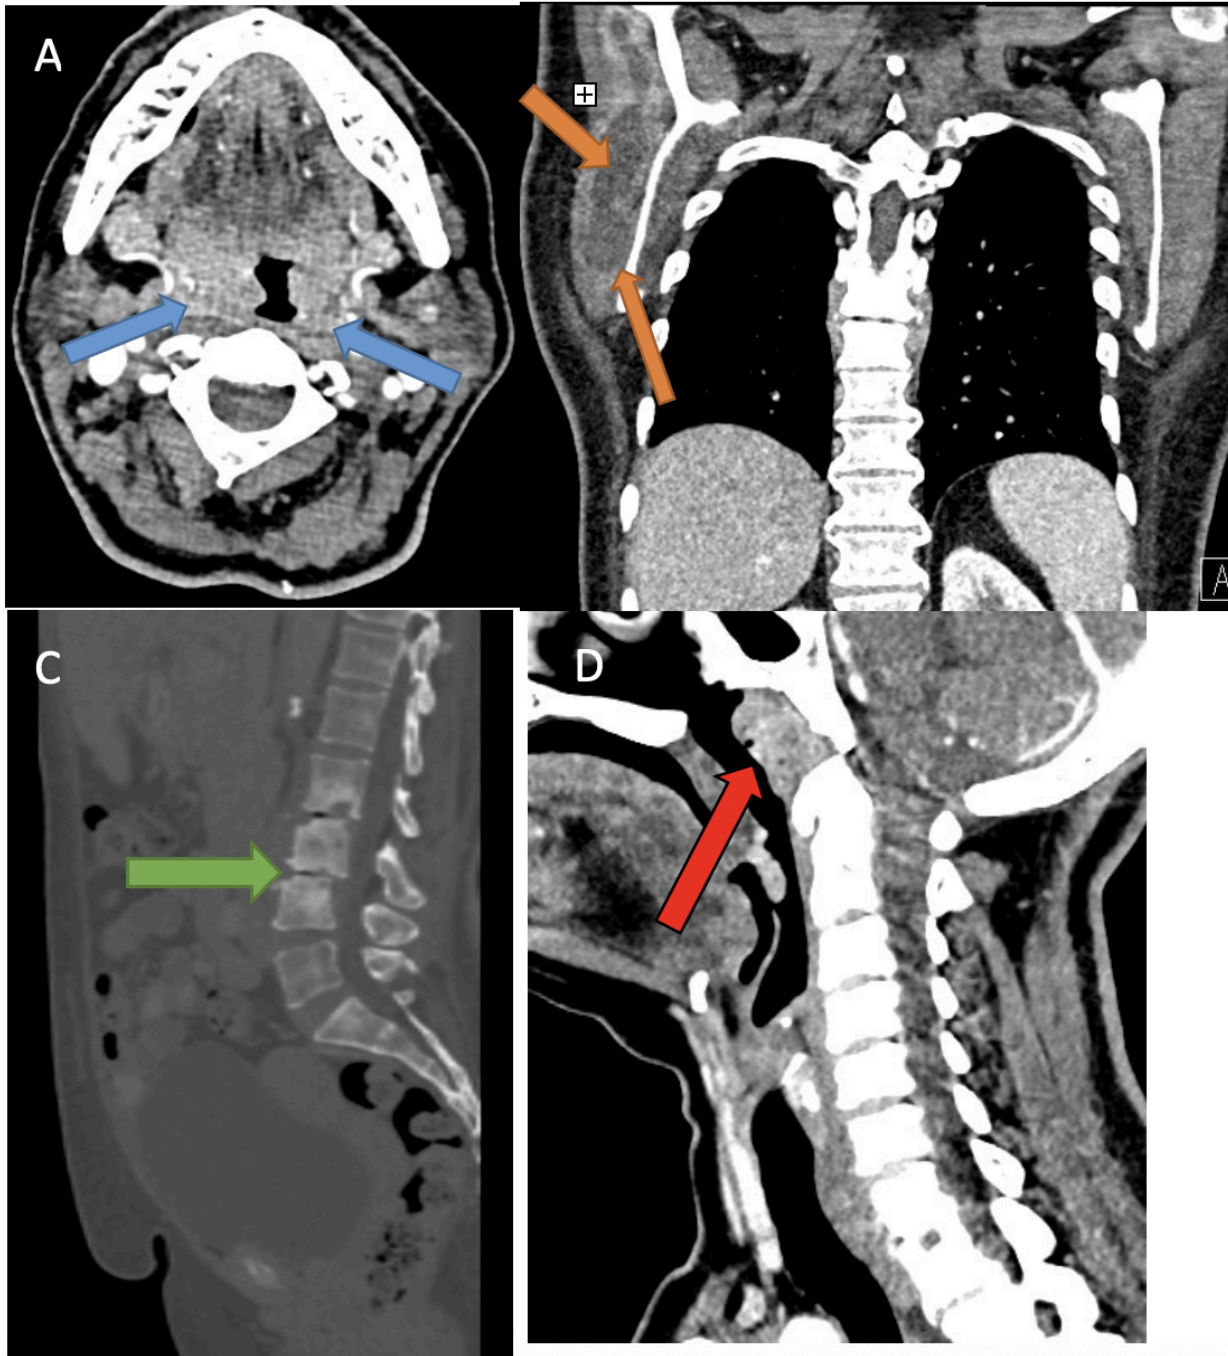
(a) Axial CT image show enlarged both tonsils (marked with blue arrow) but no definite evidence of low density to suggest any collection. (b) Coronal reformatted image of the chest show, that there is a collection noted in right supra and infraspinatus muscle region which is showing central low density and is showing peripheral enhancement (marked with orange arrow). (c) Sagittal CT reformation of lumbar spine show multilevel bony sclerosis involving L2, L3 and L4 vertebral bodies with bony sclerosis and reduced intervertebral disc space heights and end plate changes (marked with green arrow). Features are more in favoring of spondylo-discitis. (d) Sagittal CT reformation of the neck show enlarged adenoids with mild narrowing of nasopharyngeal airway (marked with red arrow)
